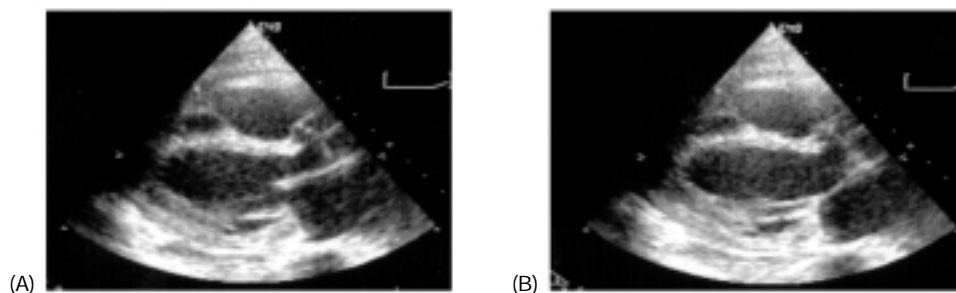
Parasternal long-axis views in end-diastole (A) and end-systole (B). Twenty-four h postpericardiocentesis frames demonstrating severely depressed left ventricular systolic function. The left ventricle is dilated and wall thickness is decreased. No pericardial effusion is seen.
